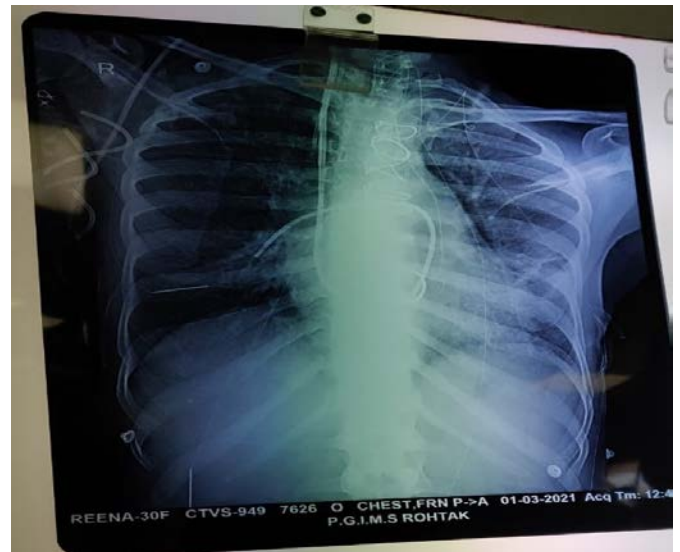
Showing chest radiograph image showing angulation of Pulmonary artery catheter
